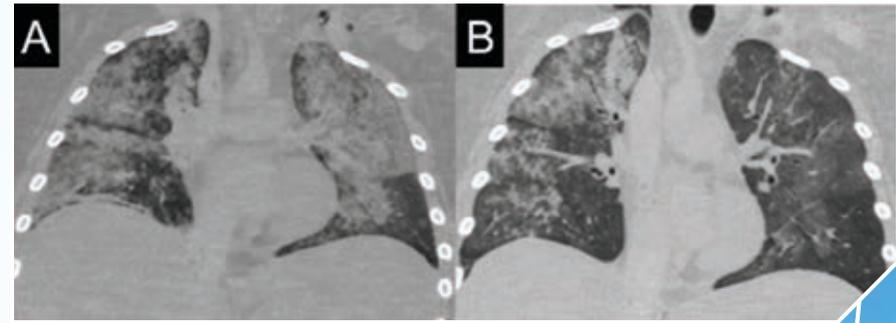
PMCT images in a case of pulmonary oedema secondary to drug death. Standard PMCT images (A) exaggerate the degree of pulmonary oedema similar to performing a clinical CT during expiration. Using ventilation during PMCT (B) mimics clinical CT during breath holding by expanding the lung, and potentially gives more accurate information.
